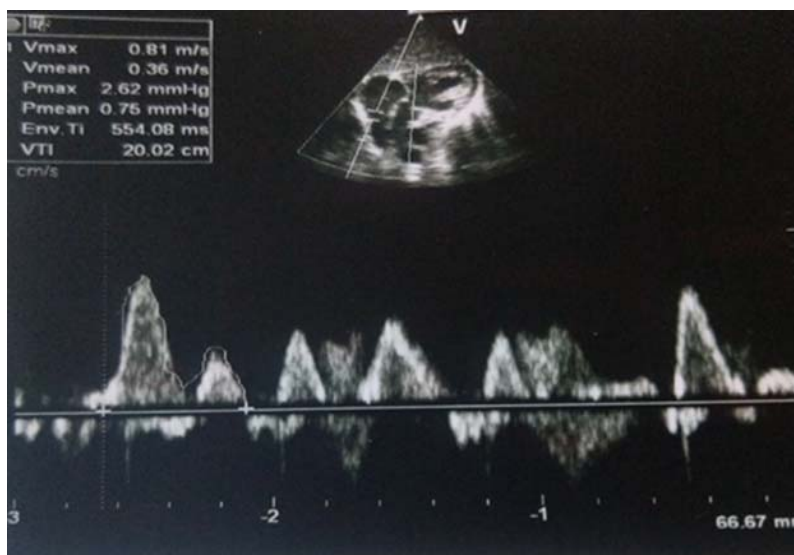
Pulsed Doppler of SVC flow from normal healthy neonate showing D wave, S wave and A wave.
